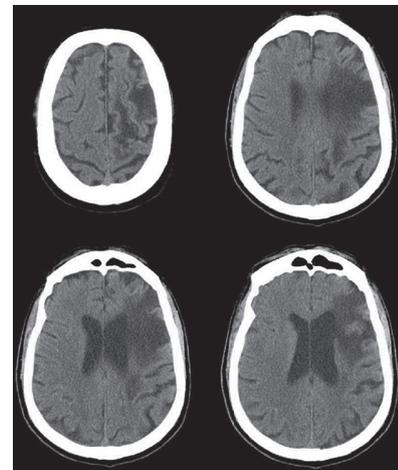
Cranial computed tomography scan revealing a left-sided cerebral infarct
